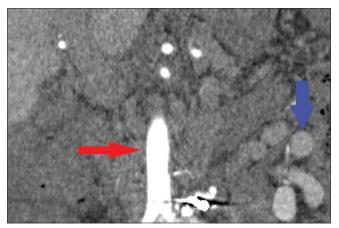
A 72-year-old male with a colonic arteriovenous malformation who presented with ascites. Contrast-enhanced CT image of the abdomen in arterial phase demonstrating the contrast enhance aorta (red arrow) and the draining portal vein nearly absent of contrast (blue arrow) suggesting marked reduction in arterial blood supply post-procedurally.
